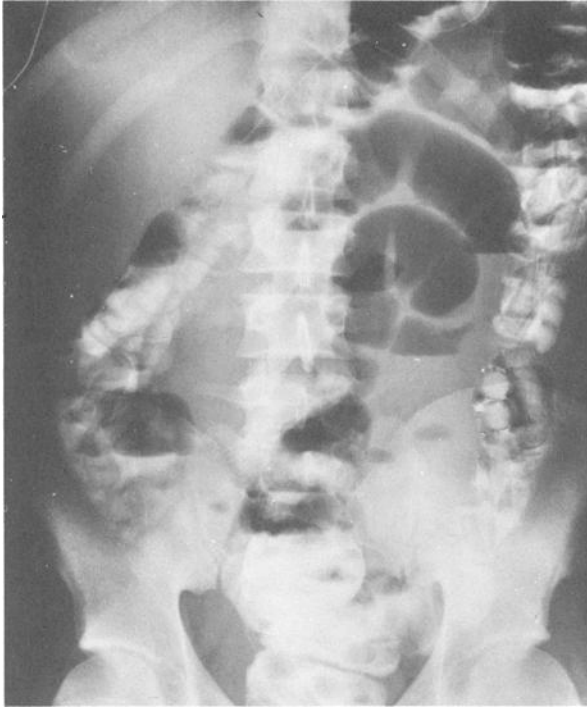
Upright roentgenogram, performed 36 h after administration of 100 mL of water-soluble contrast compound, showing small bowel obstruction and foreign bodies.
